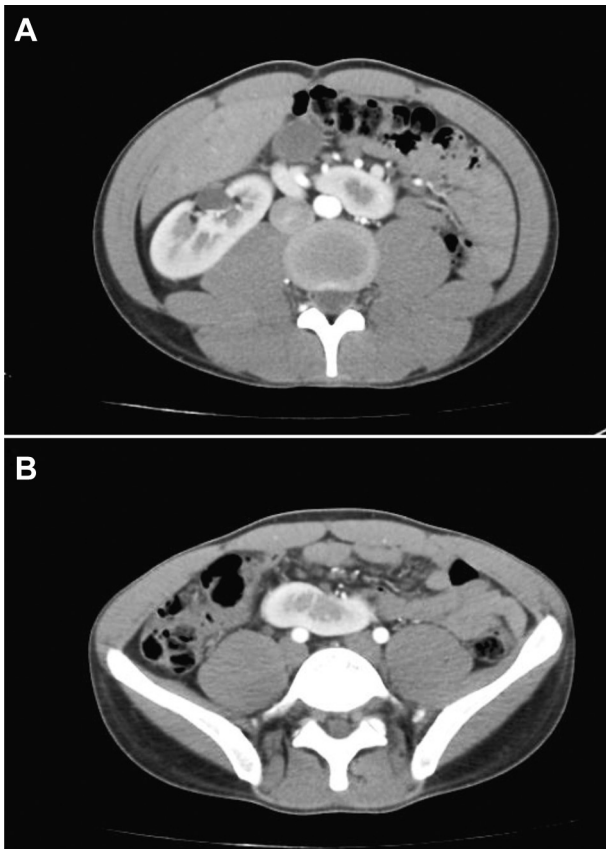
Computed tomographic image of crossed renal ectopia.
